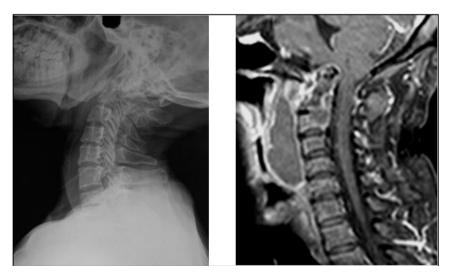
Cranio-vertebral junction (CVJ) tuberculosis. (A): Lateral radiograph of cervical spine showing increased prevertebral soft tissue. (B): Sagittal TIW FS CE MRI sequence shows altered signal intensity of C2 odontoid process and body which shows contrast enhancement. There is associated prevertebral collection with increased atlantoaxial distance and with basilar invagination. Kinking and compression at cervicomedullary junction is seen.
